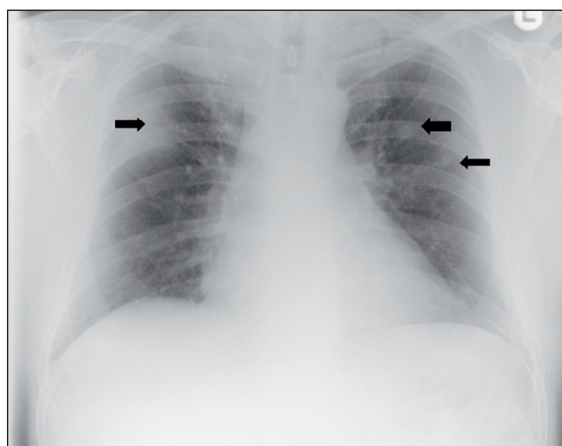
(a). Chest x-ray – arrows indicate pulmonary infiltrates.
